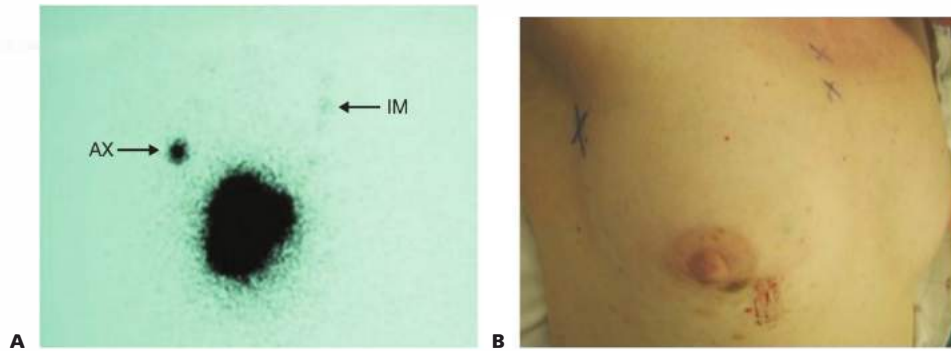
• A. Lymphoscintigraphy demonstrating intense radioactivity in the right axillary node basin and very faint radioactivity in the internal mammary basin. B. Note “X” marks placed by the nuclear medicine technician to guide gamma probe examination.
